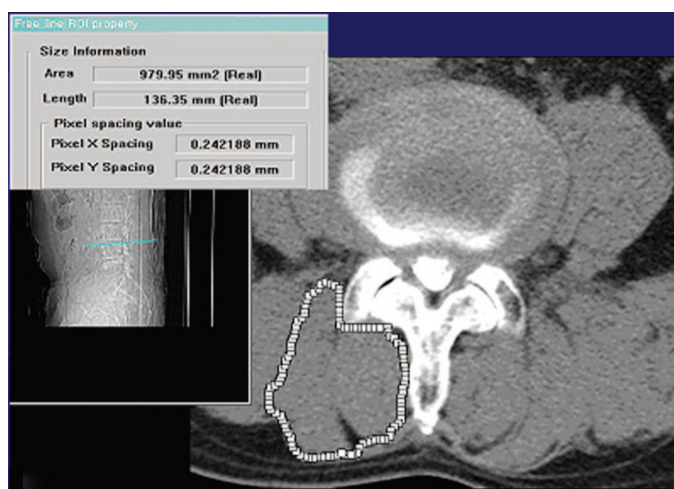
Cross-sectional area measurement of the longissimus and multifidus muscles using a CT scan at the upper endplate of the L4-L5 body.
